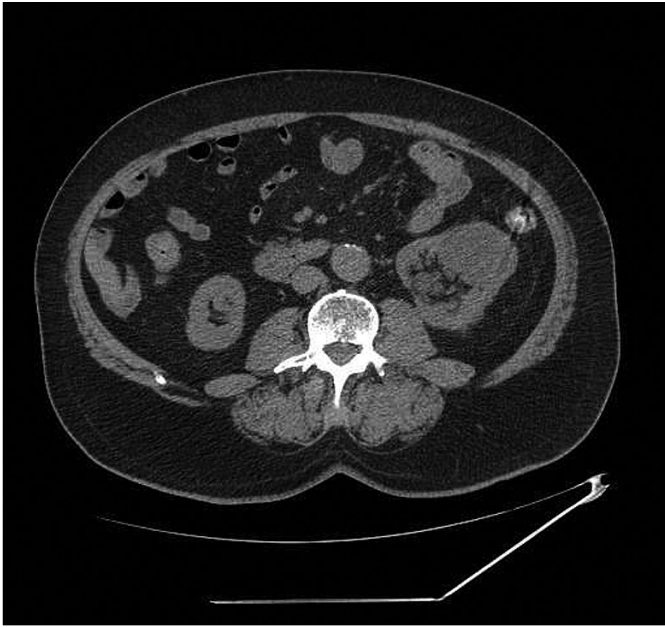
Computed tomography scan revealed a left kidney tumor mass.
